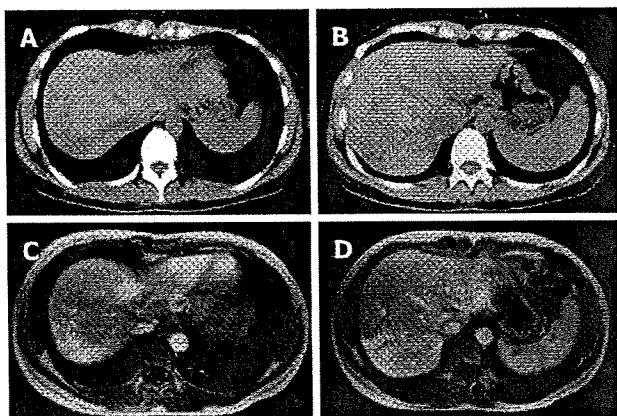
A, B: Abdominal CT at the onset of hepatic encephalopathy; C, D: Enhanced abdominal MRI.
